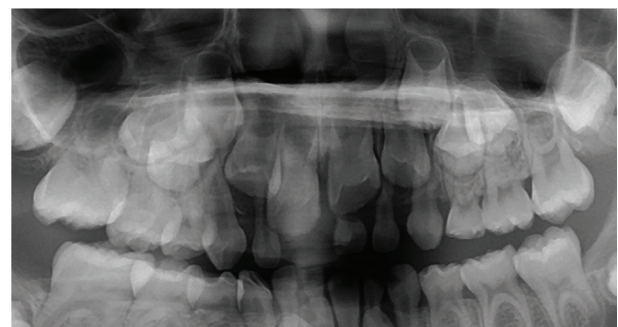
Cropped panoramic radiograph revealing no bony changes associated with the lesion.
